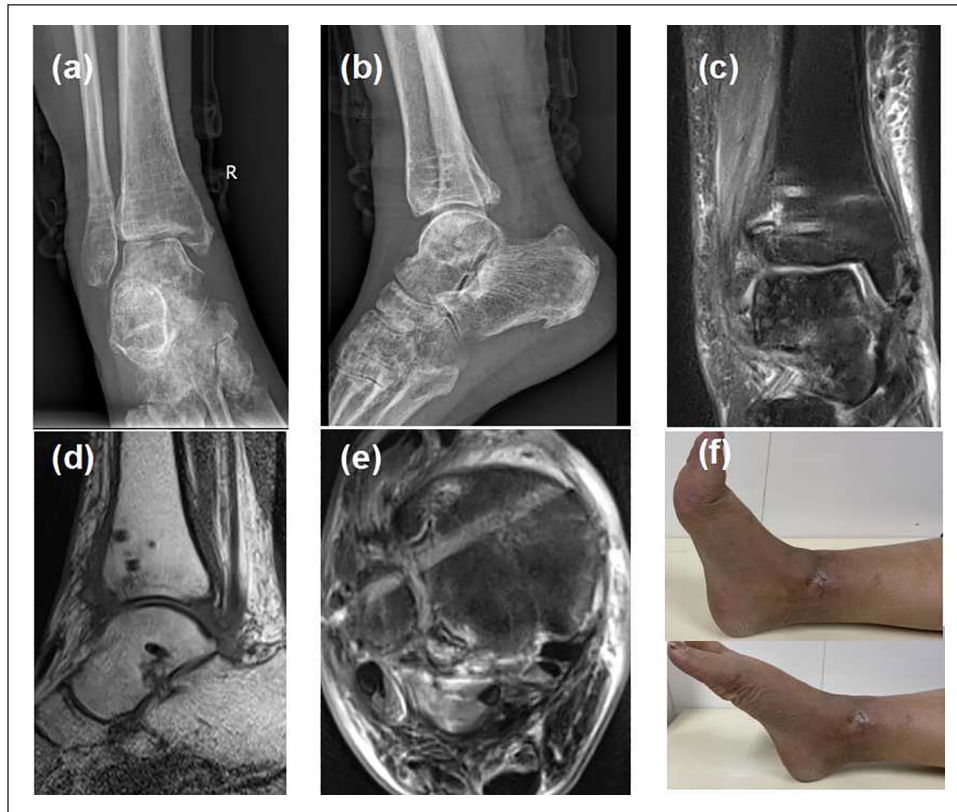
Patient showed good imaging appearances and a satisfactory clinical outcome after removing the hardware, 15 weeks after surgery. (a, b) Radiographs on AP and lateral view showing the normal position of the ankle. (c) Continuous appearance of the deltoid ligament on the coronal view of ankle MRI. (d, e) Tibiotalar joint and syndesmosis on sagittal and axial views of MRI. (f) Pain-free range of motion of the ankle with active dorsiflexion and plantar flexion.
